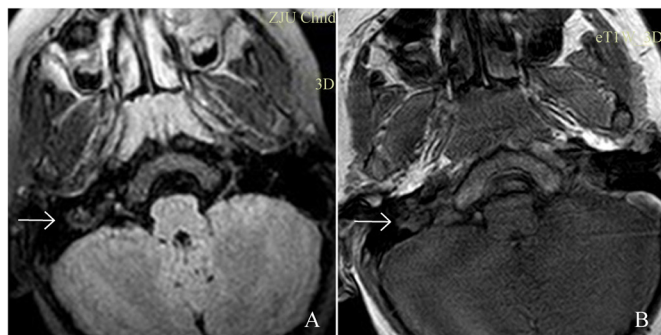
MRI features of the inner ear before treatment in a 7-year-old boy with vestibular hemorrhage in the right ear. (A) Three-dimensional fluid-attenuated inversion recovery (3D-FLAIR) axial image. (B) T1-weighted image (T1WI) axial image. The arrows indicate right vestibular hyperintensity.
